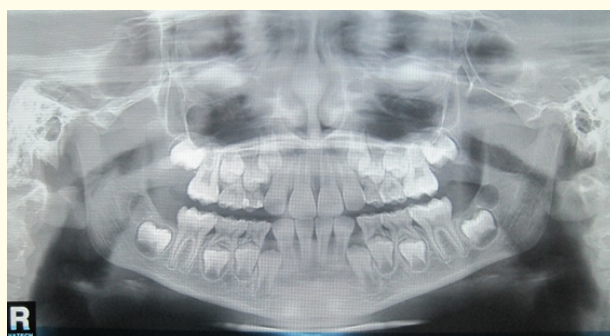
Panoramic radiograph showing displacement of the unilateral condyle fracture.
